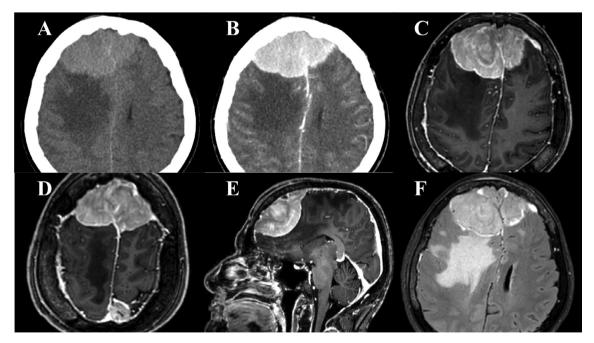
Preoperative (A) non-contrast and (B) contrast head CT, (C, D) axial, (E) sagittal T1-weighted gadolinium-enhanced and (F) axial fluid-attenuated inversion recovery (FLAIR) MRI showing multiple contrast-enhancing parasagittal lesions in a 73-year-old woman with significant surrounding brain edema.
